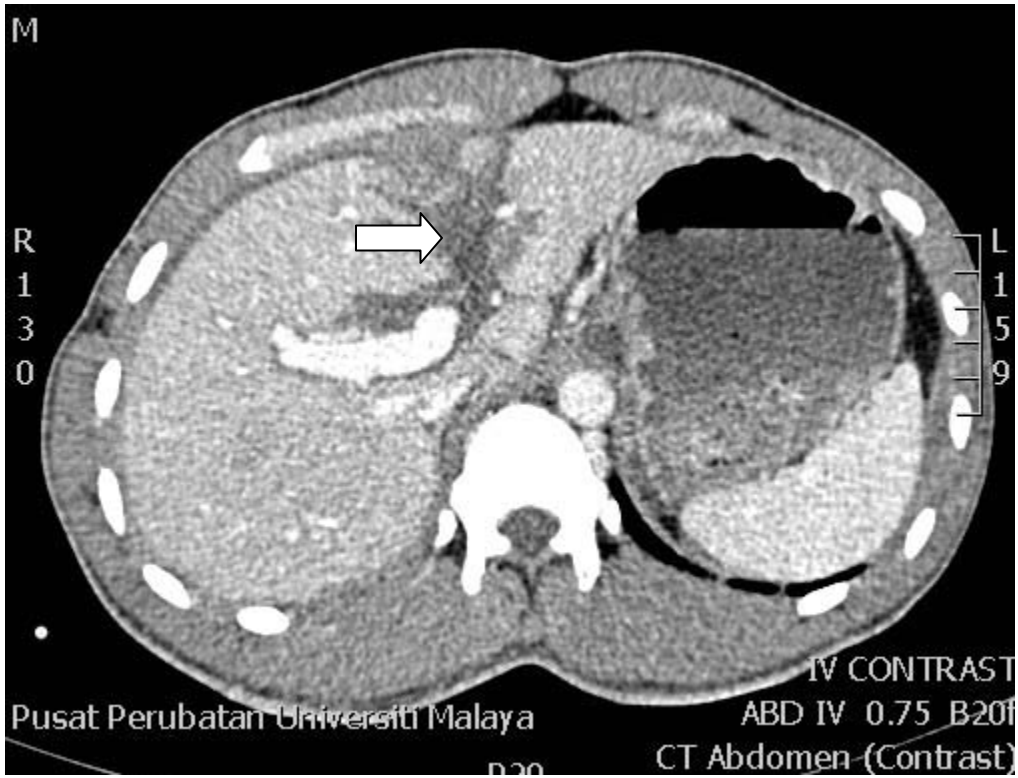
Axial computed tomography scan of the abdomen shows a hypodense laceration of the liver (arrow).
